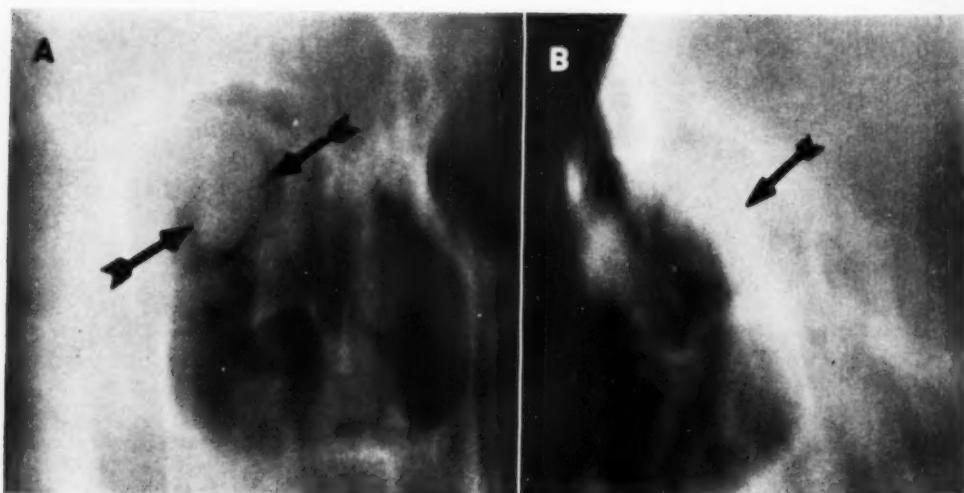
A. Radiographic section in rotated frontal position at 3 cm. demonstrates a large tumor in the posterior portion of the orbit.
